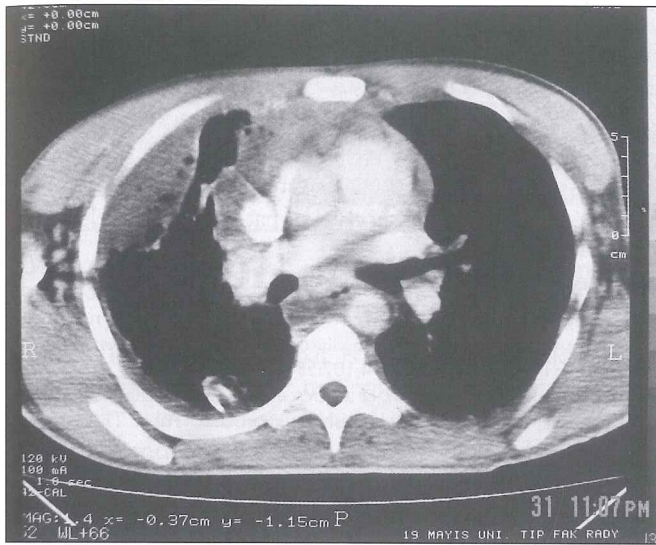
Preoperative thoracic CT showing anterior and posterior mediastinal abscess, gas bubbles and effusion on the right side.
